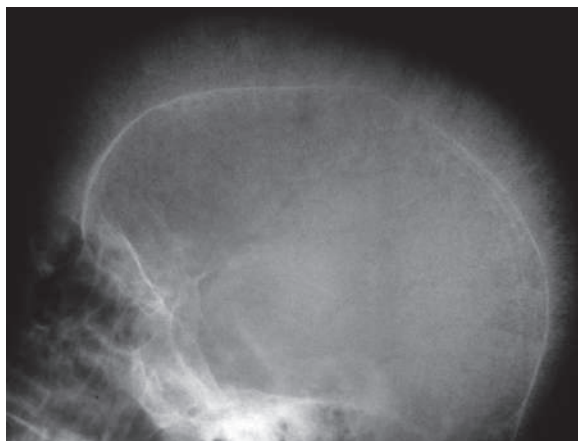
A plain radiograph of the lateral skull of a patient with thalassemia shows hair-on-end appearance
